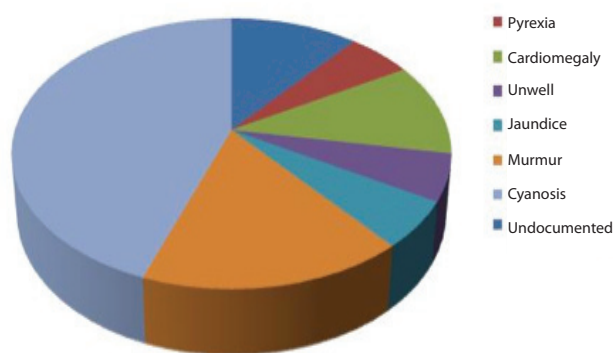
Presentations from tele-echocardiography.
